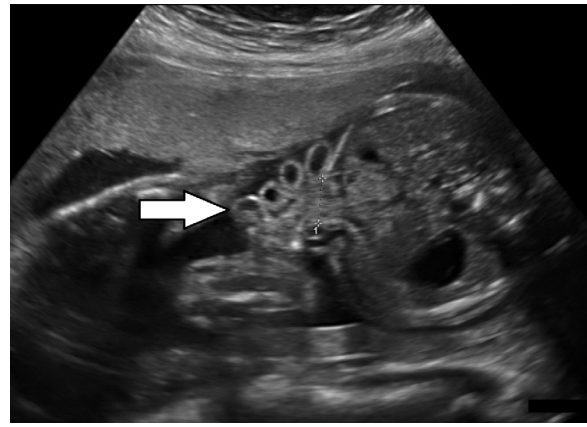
An ultrasound image of a foetus with gastroschisis. The arrow indicates free floating intestine in the amniotic fluid. The markers span the diameter of the abdominal wall defect.
